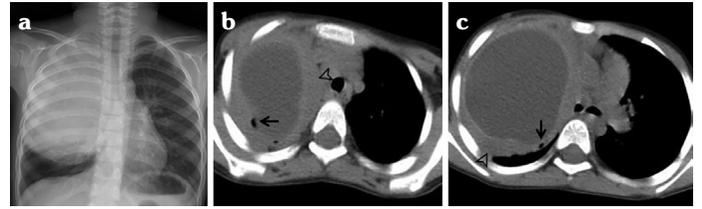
Images of a 5-year-old patient with a giant cyst and a contained rupture in the right lung. (a) Chest radiography showing a well-defined round radio-opacity in the right lung. (b, c) Axial computed tomography images show air blebs (arrows) between the pericyst and the endocyst, indicating rupture (signet ring sign) and parenchymal consolidation (arrowheads) around the cyst
